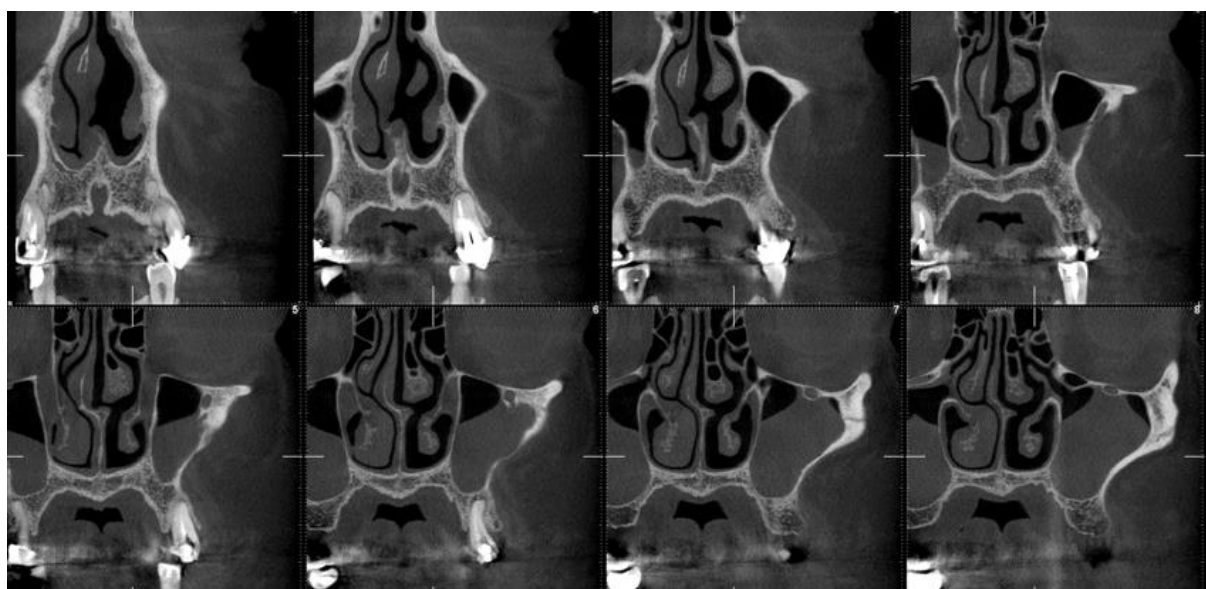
Transverse CBCT sections showing the large changes in the membrane and the left sinus cavity as a result of the presence of the neof ormation
